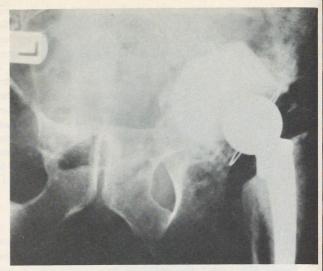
Postoperative AP radiograph of pelvis of patient described in Figure 5. The lesion has been removed and a new acetabular floor created with methylmethacrylate. A total hip arthroplasty has been done.
